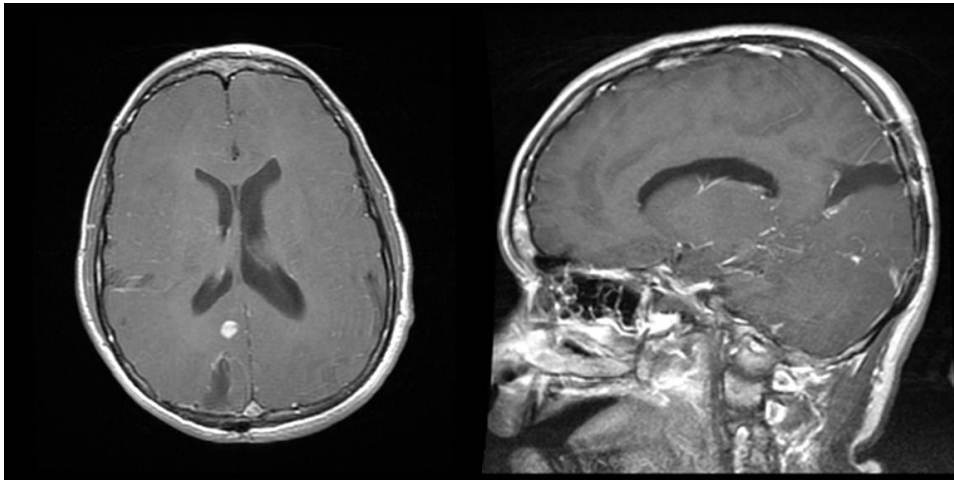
Postoperative axial and sagittal MRI in case 1 show no residual or recurrent tumor. The surgical corridor created by the D³ from the brain surface to the resection cavity is well visualized. The deeper lesion adjacent to the splenium was not removed.
